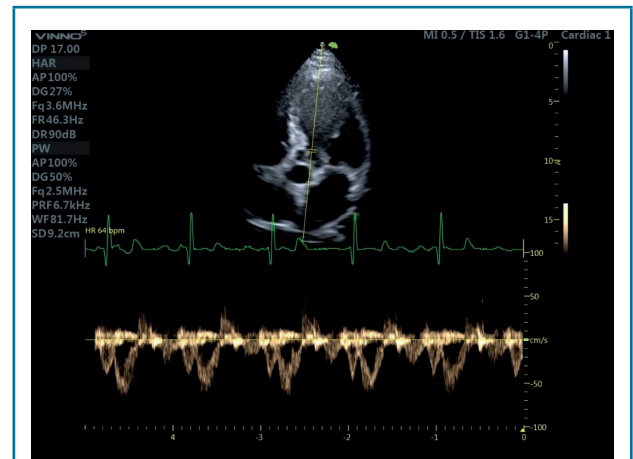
Pulse wave Doppler evaluation in LVOT demonstrating presystolic wave
